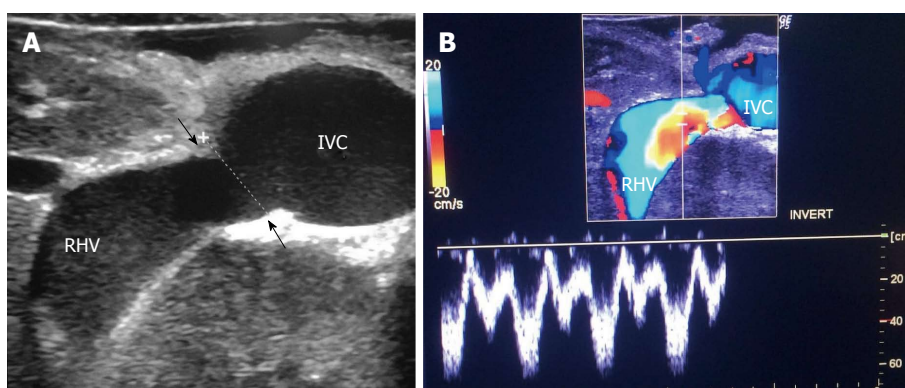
Intra-operative ultrasound evaluation of right hepatic vein anastomosis. A: B-mode US image showing RHV with end-to-side anastomosis with the IVC; B: Color Doppler image showing normal triphasic waveform of the RHV. RHV: Right hepatic vein; IVC: Inferior vena cava.
